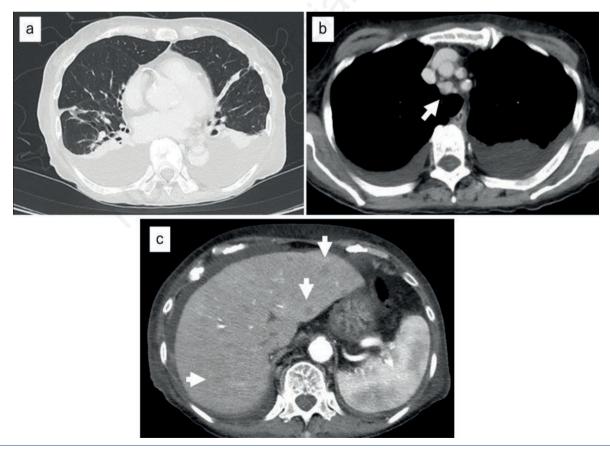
a) Chest CT (lung window) shows emphysema, fibrosis, some frosted shadows, enlarged mediastinal lymph nodes, and pleural effusion. b) Chest CT (mediastinal window) shows enlarged mediastinal lymph node (arrow). c) Contrast enhanced computed tomography shows an enlarged spleen and multiple nodules in liver (arrows), without abdominal lymphadenopathy.
